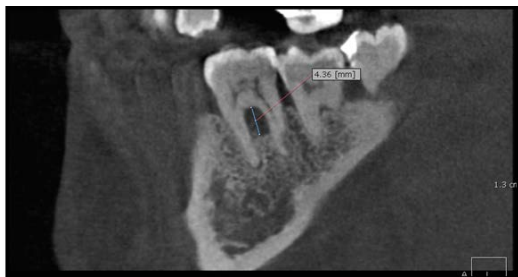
CBCT BL-V measurement
